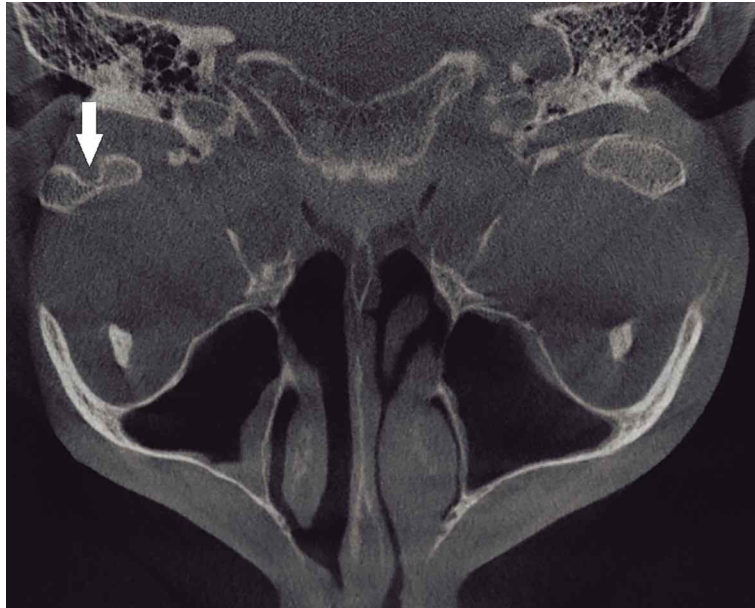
An axial CBCT slice revealing the duplication of the left mandibular condyle mediolaterally (arrow).
